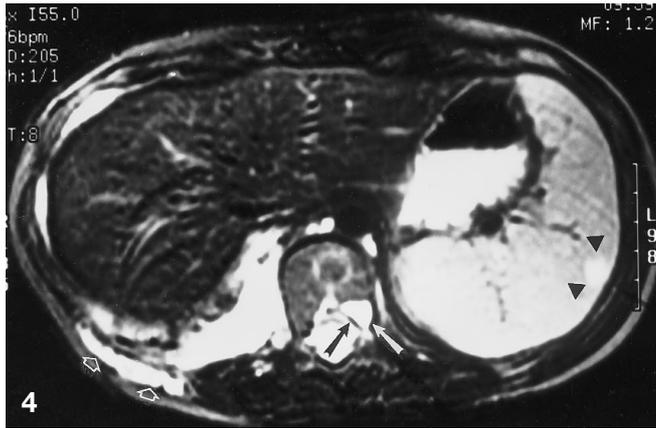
A T2-weighted axial spin-echo image (TR/TE: 2307/102) demonstrates high-signal intensity corresponding to sites of lytic rib lesions (*open arrows*). Focal high signal intensity is also noted in the left posterior portion of the vertebral body (*solid arrows*). Additionally, similar focal high signal is present in the spleen, consistent with splenic involvement (*arrowheads*) (courtesy of Sara M. O'Hara, M.D., Duke University)
